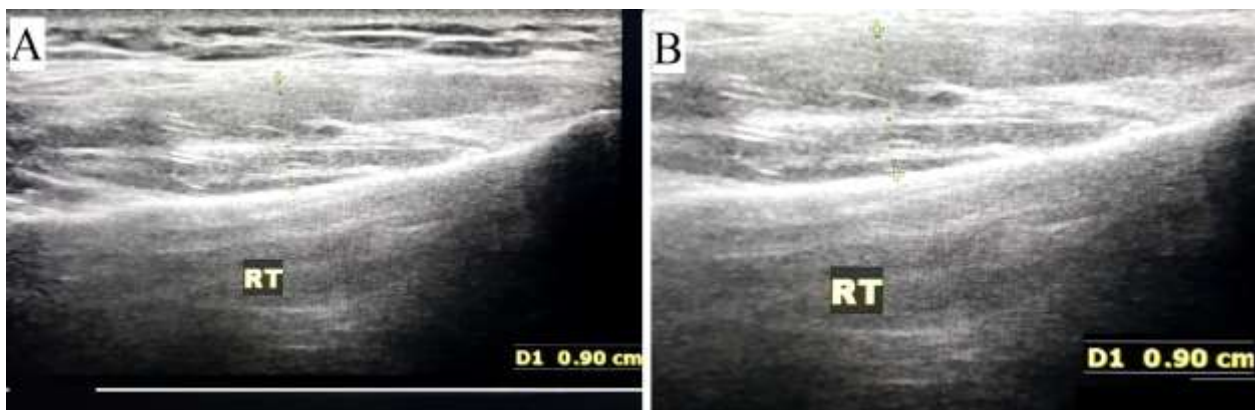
Ultrasound examination of the masseter muscle. A: Before treatment. B: After treatment
